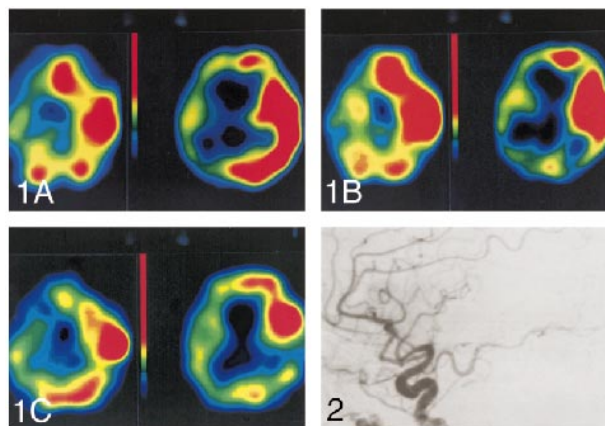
HMPAO SPECT 2 days (A), 6 days (B), and 19 days (C) after stroke onset (Case 2).
